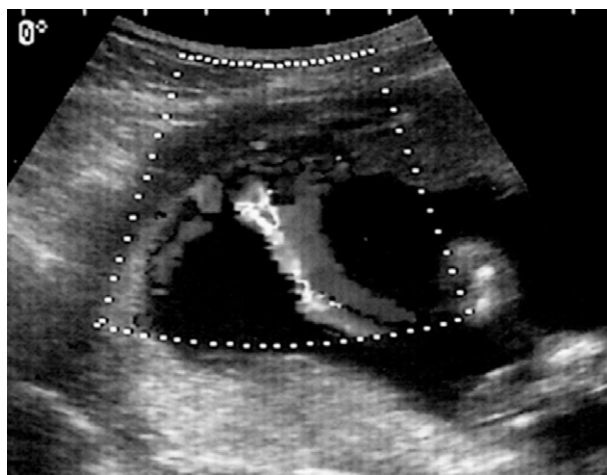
Ultrasound image of velamentous cord insertion in the mid-trimester.
